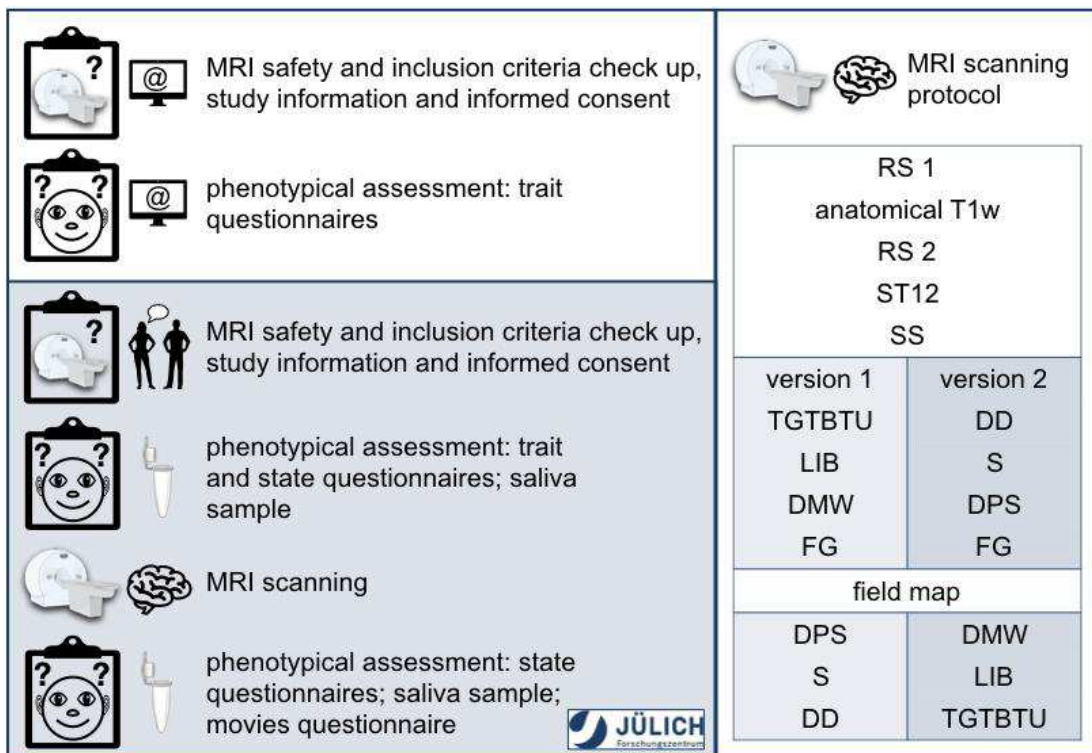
Overview of study and MRI protocols. The left side depicts the overall study protocol. Participants were first screened for inclusion criteria, if study participation was possible, participants next filled out online questionnaires assessing a range of traits. Then participants partook in the on site appointment including trait and state phenotypical assessment and MRI scanning. The right side depicts the MRI scanning protocol, including two versions of the movie watching protocol. RS = resting state, ST12 = short term 12, SS = short sequences, TGTBTU =
